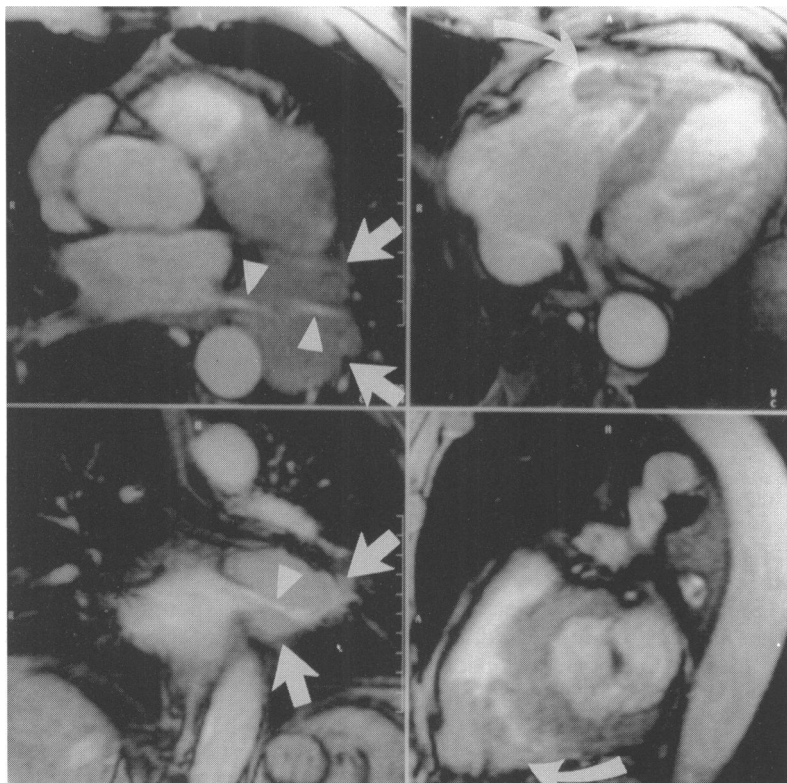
Breath held gradient-echo magnetic resonance images ($TR/TE/\text{flip angle} = 131/7.3/20^\circ$) acquired during diastole. Left upper and left lower: axial and coronal images, respectively, at the level of the left atrium showing a tumour (arrows) encasing a left pulmonary vein (arrow heads). Right upper and right lower: axial and sagittal images, respectively, at the level of the left and right ventricles demonstrating the tumour (curved arrow) extending from the right ventricular wall into the right ventricular chamber.
